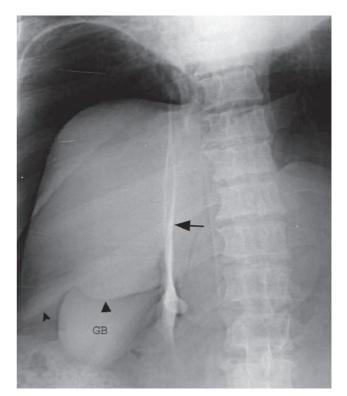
Plain abdominal radiograph reveals massive pneumoperitoneum. The falciform ligament (arrow), hepatic edge (arrowheads) and gallbladder (GB) are outlined by intraperitoneal air
